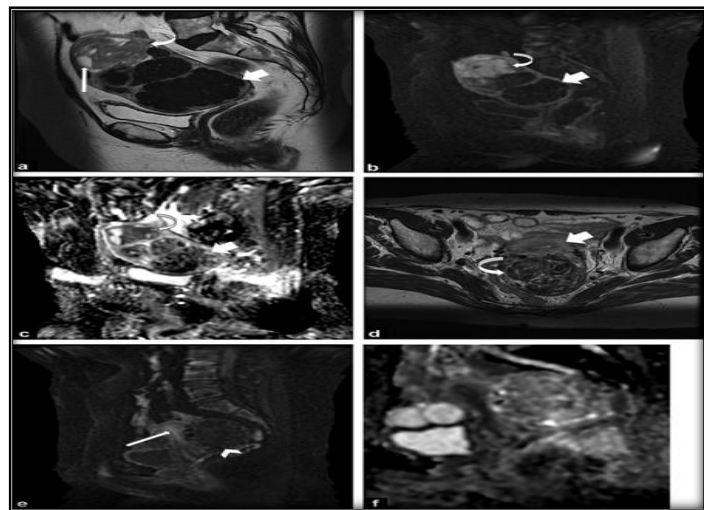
DWI and ADC maps of uterine tumours. (a–c) leiomyosarcoma showing intermediate T2 signal with necrosis (a), high signal on b1000 DWI (b), and restricted diffusion with low ADC ($873 \times 10^{-3} \text{ mm}^2/\text{s}$) (c). Coexisting benign leiomyomas show low T2 and DWI signal with lower ADC ($796 \times 10^{-3} \text{ mm}^2/\text{s}$). (d–f) A 67-year-old woman with atypical leiomyoma showing heterogeneous low T2 signal (d), no restriction on DWI (e), and high ADC ($1661 \times 10^{-3} \text{ mm}^2/\text{s}$) (f). Final diagnosis confirmed post-hysterectomy.
